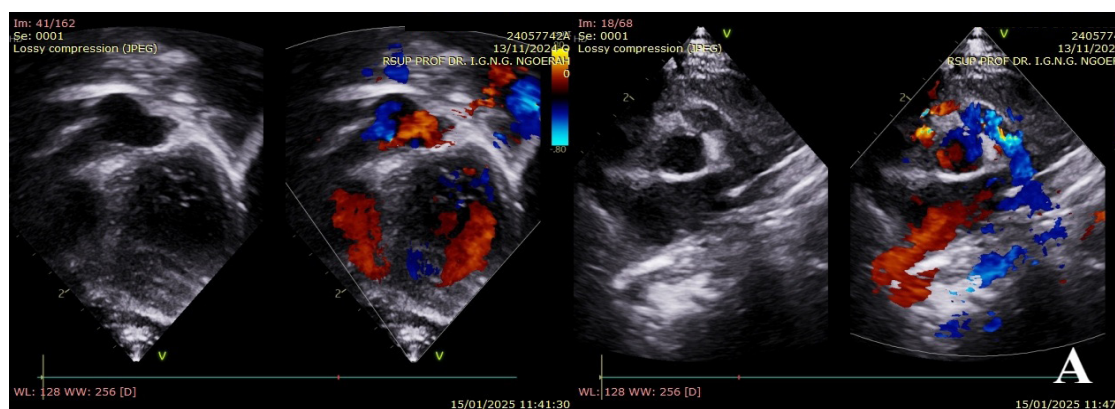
Echocardiography examination showing tricuspid atresia with atrioventricular discordance, hypoplastic right ventricle, large ASD with right-to-left shunt, restrictive VSD, and absence of PDA.
